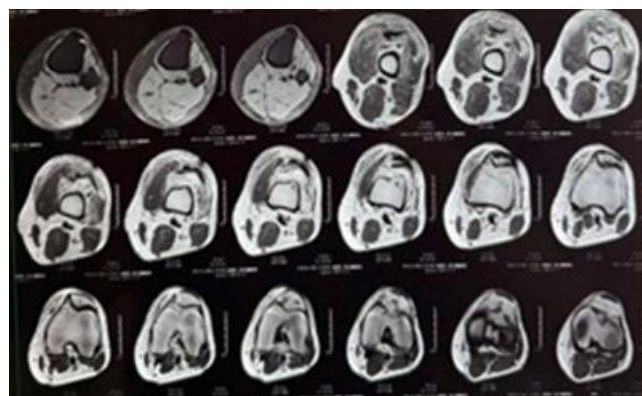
(b): Axial PD-FS MRI showing the level of tendon disruption and surrounding oedema
